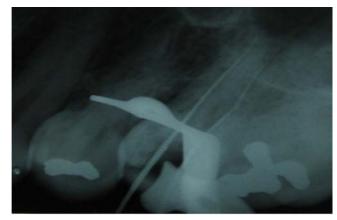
Radiographic images of the sequence of clinical treatment applied. Files indicating positioned buccal and palatal canals and between them the vestibule-palatine canal.
